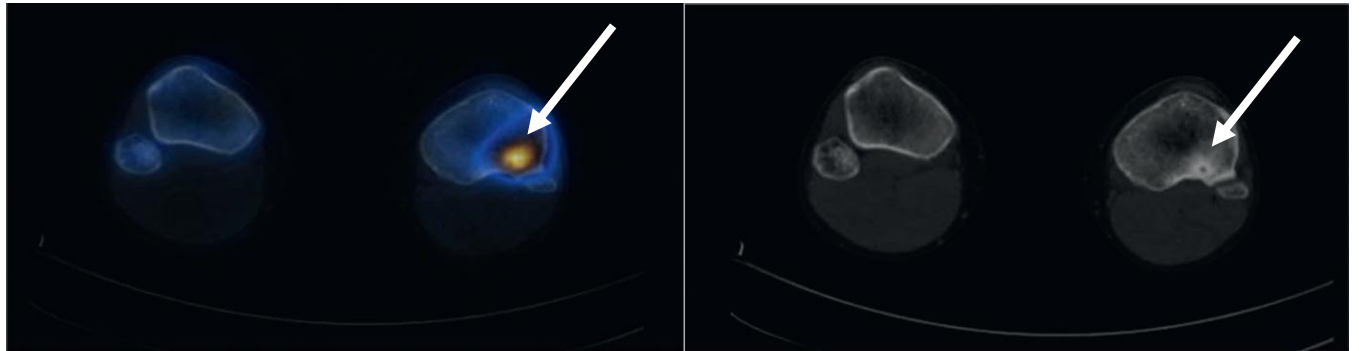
Tc-99m MDP bone SPECT/CT. Patient with left knee pain. (Left) Axial SPECT/CT show focal intense increased tracer uptake in the posterolateral aspect of the left distal femur, which corresponds to a sclerotic lesion on CT (Right) with central lucency due to an osteoid osteoma.
